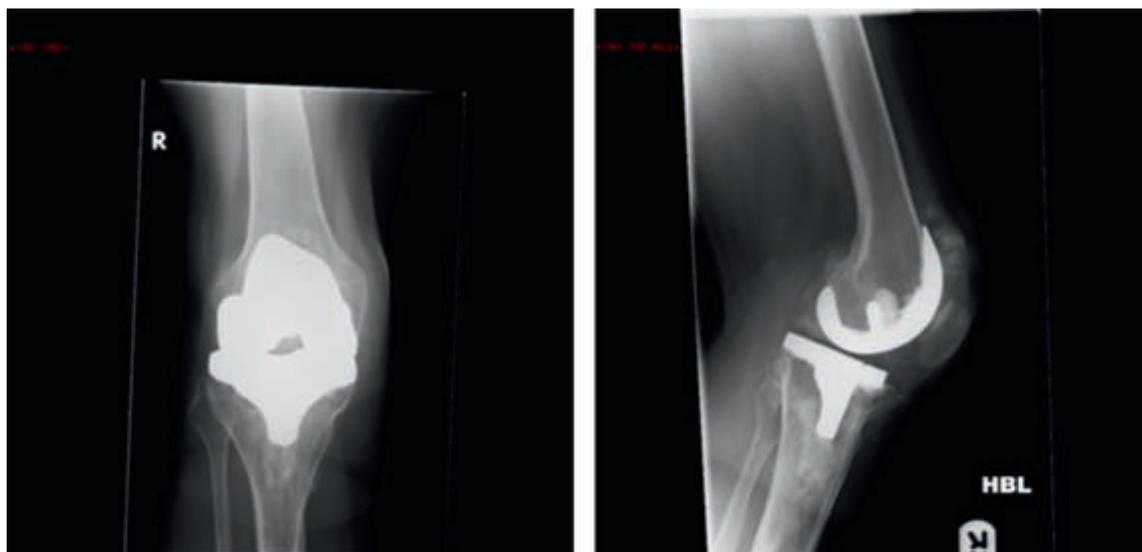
Anteroposterior and lateral radiographs of the right knee, showing a comminuted periprosthetic patellar fracture.
